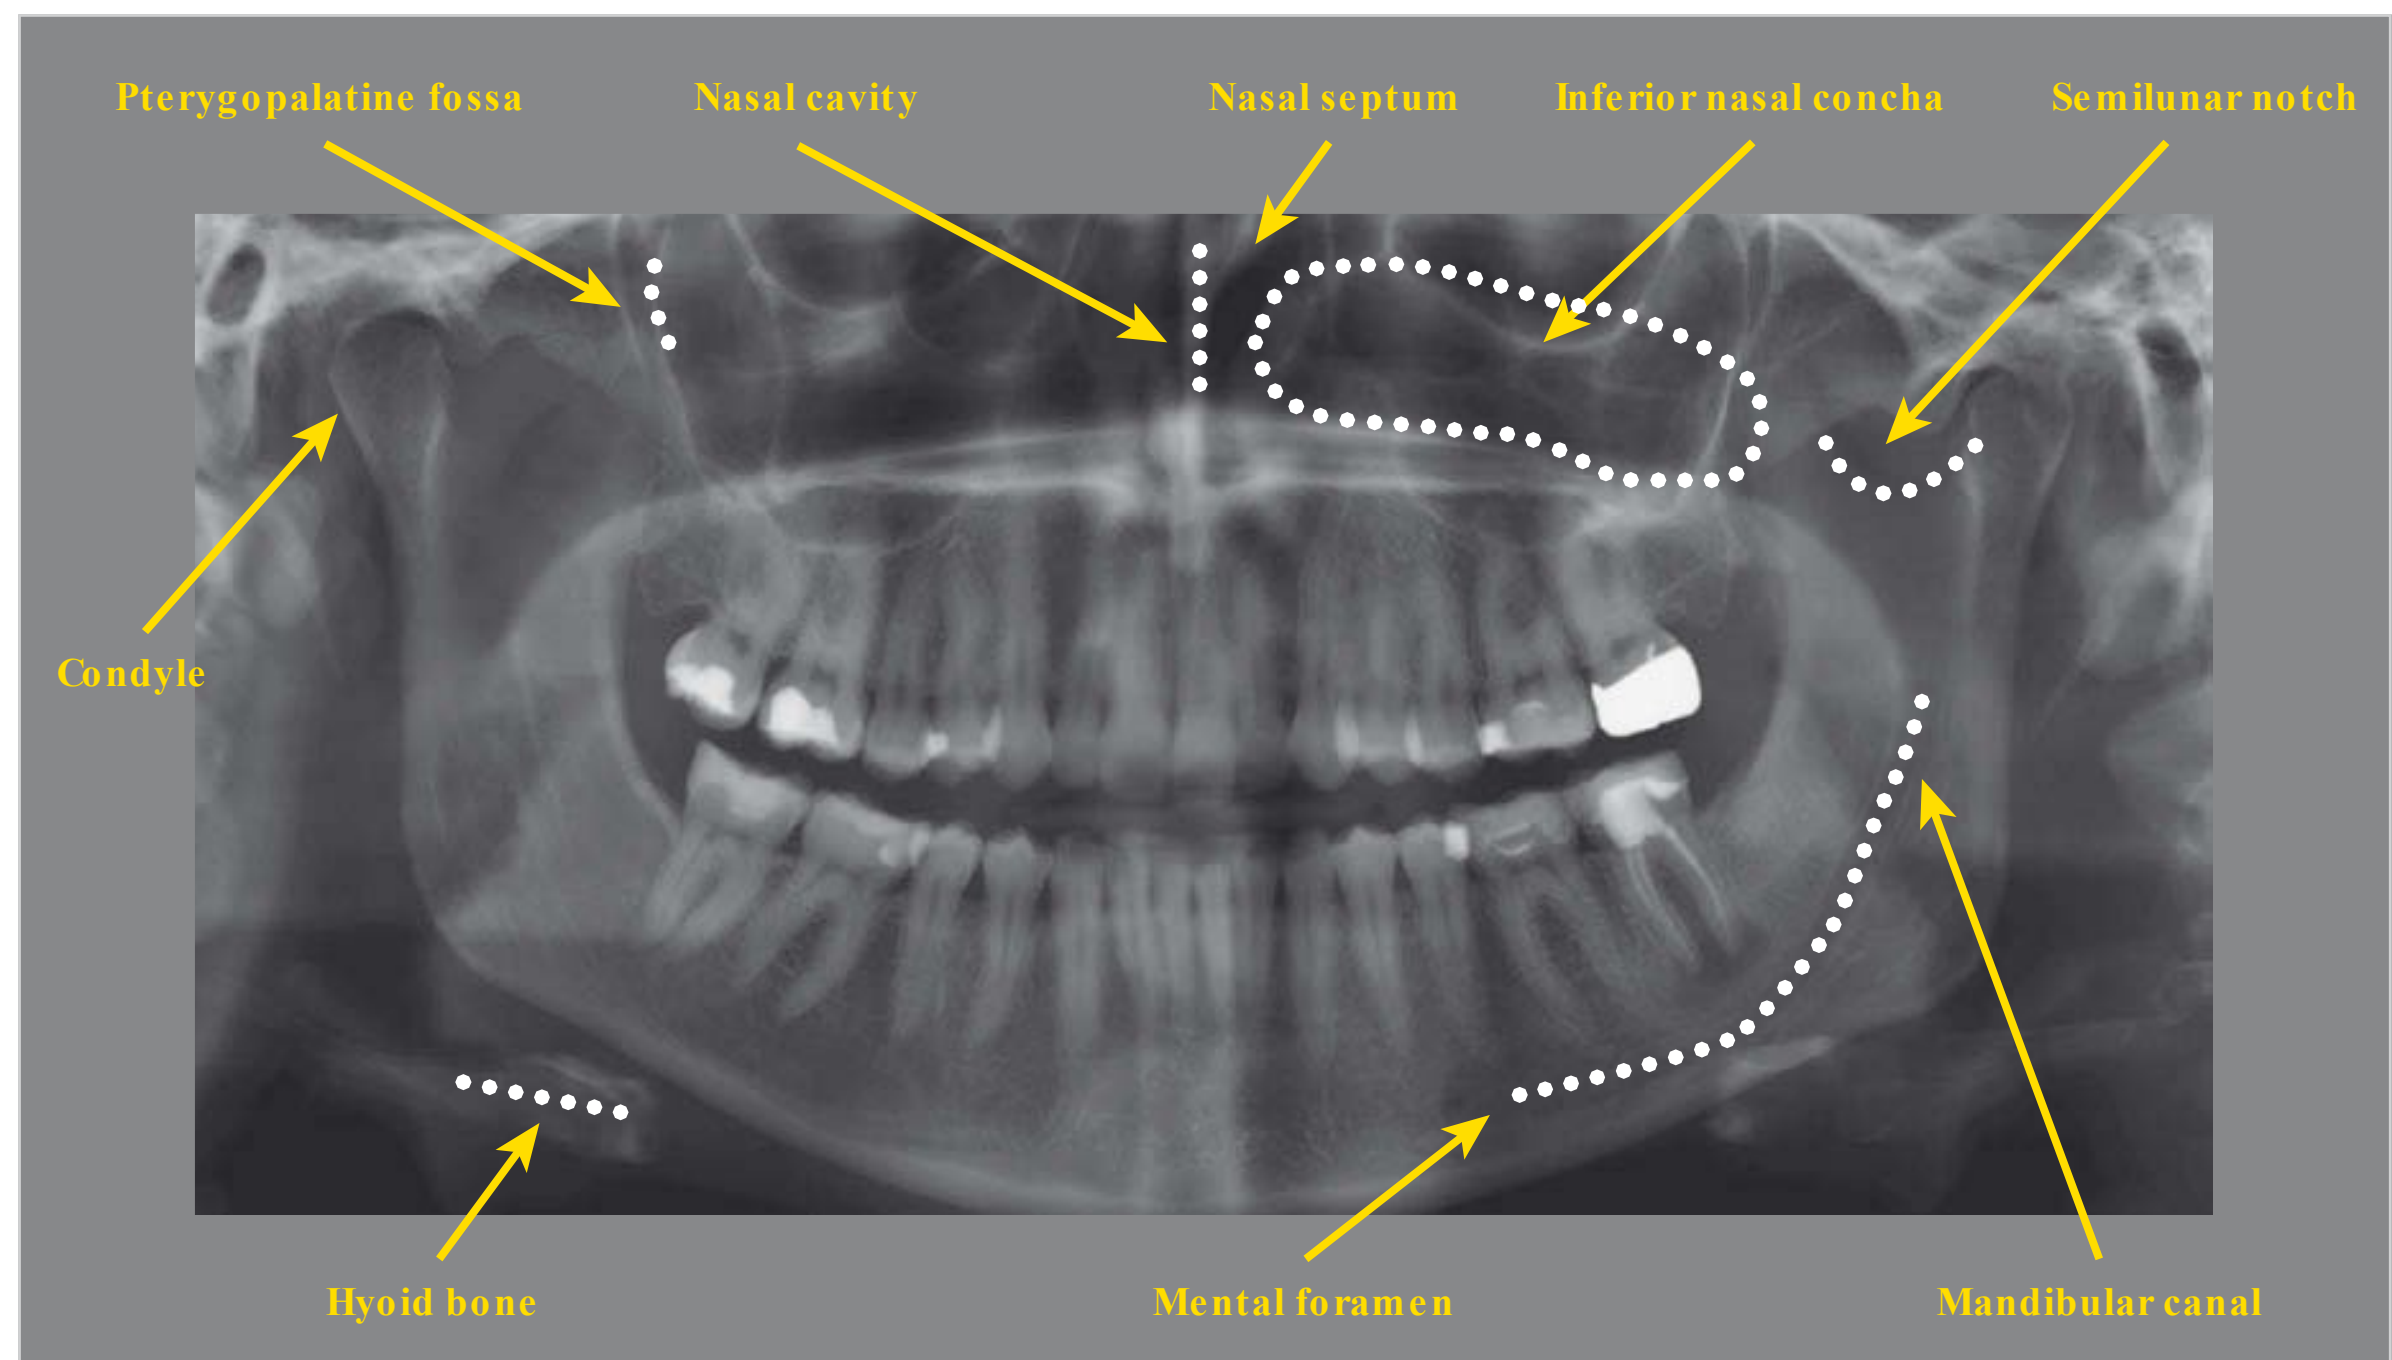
Panoramic radiography: anatomical structures III.
